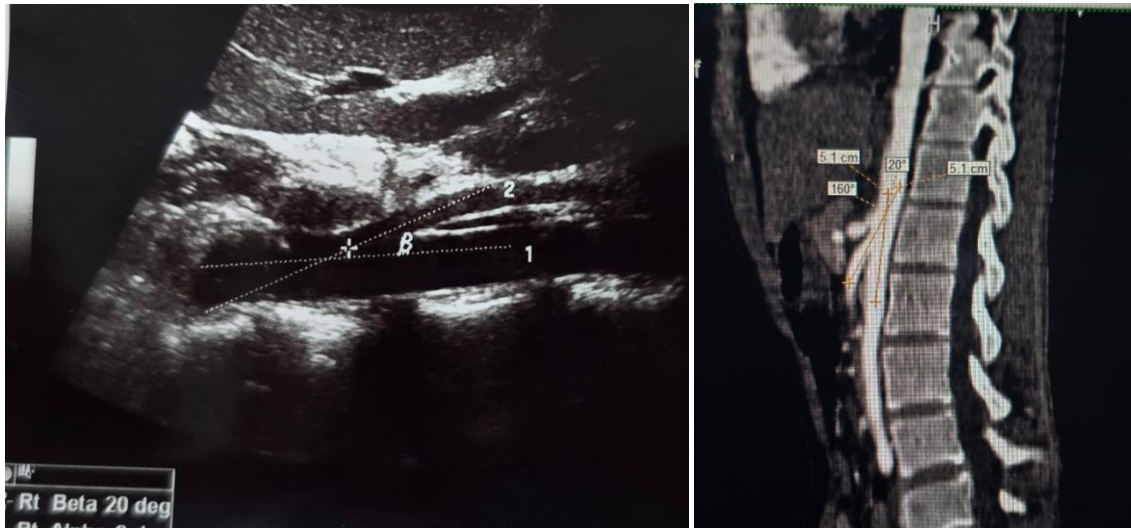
A) A doppler ultrasound study of 18-year-old male with suspected SMA syndrome shows an AMA of 20° which was proved to have certain diagnosis of SMA syndrome. B) A CTA for the same patients with AMA of 20° too.
